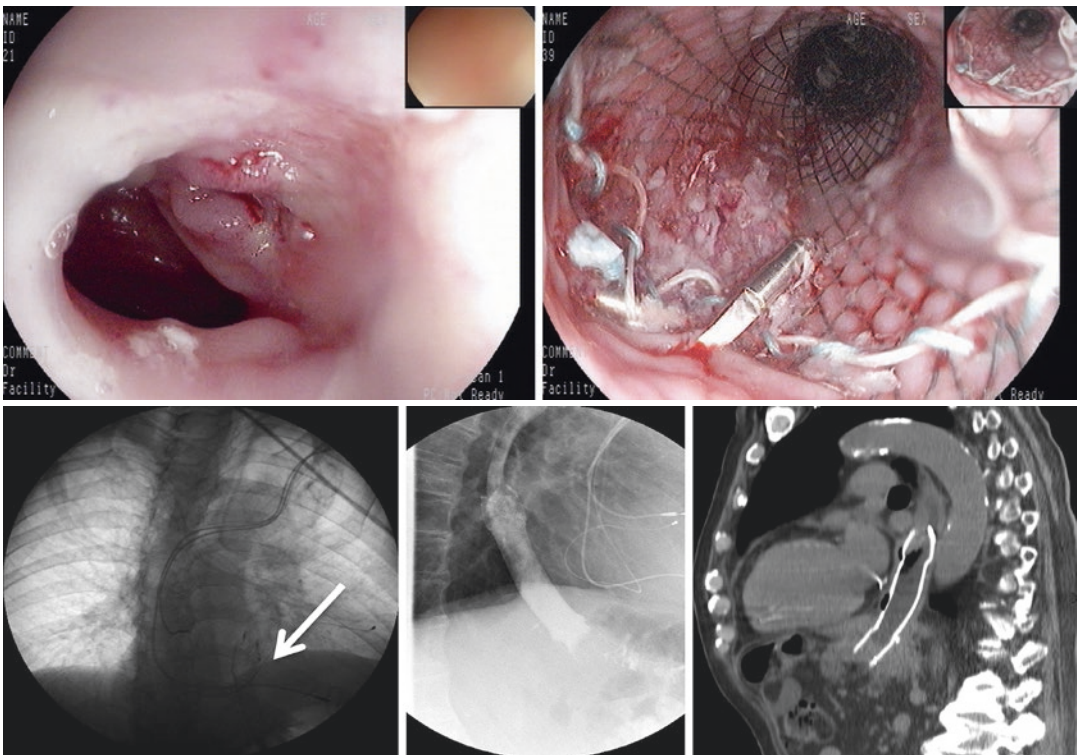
Locoregional failure after total gastrectomy for Siewert III cancer. Palliation with a self-expanding metallic stent the radiograph indicates successful placement of stent (white arrow)
